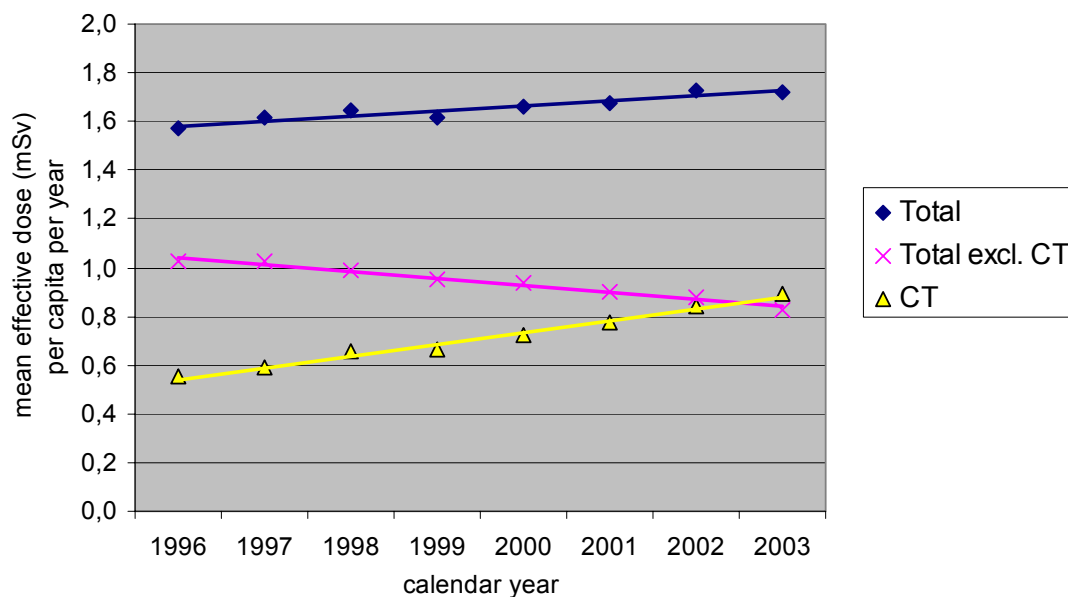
Annual effective dose (mSv) per capita due to x-ray diagnostics in Germany for 1996 to 2003
